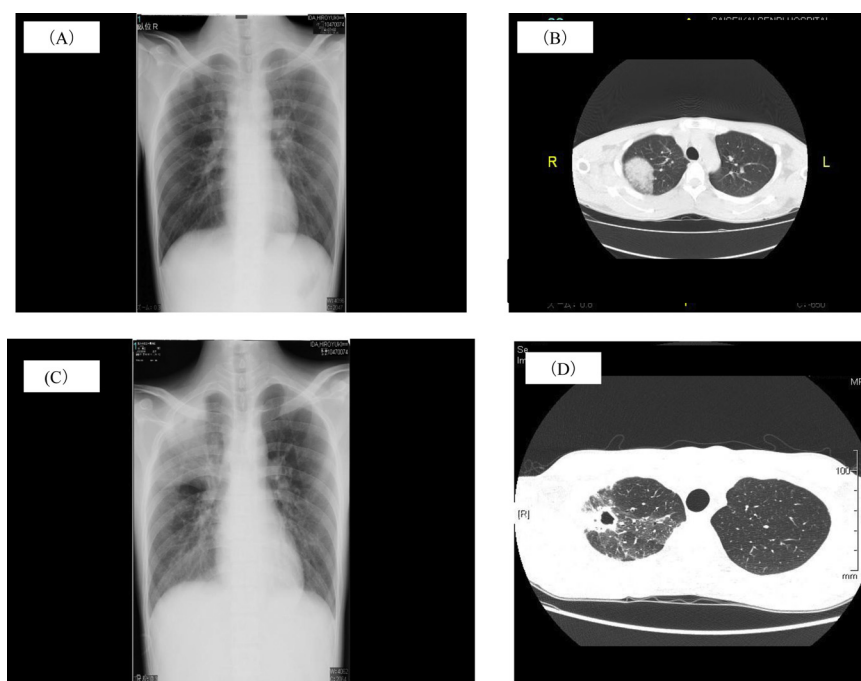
Chest radiography and computed tomography images of a 29-year-old patient admitted with CAP in June 2012 and August 2012. Chest radiography and computed tomography images in June 2012 (A and B, respectively) show patchy airspace opacity in right upper lung lobe. Those acquired in August 2012 (C and D, respectively) show right upper lobular pneumonia with cavity.
